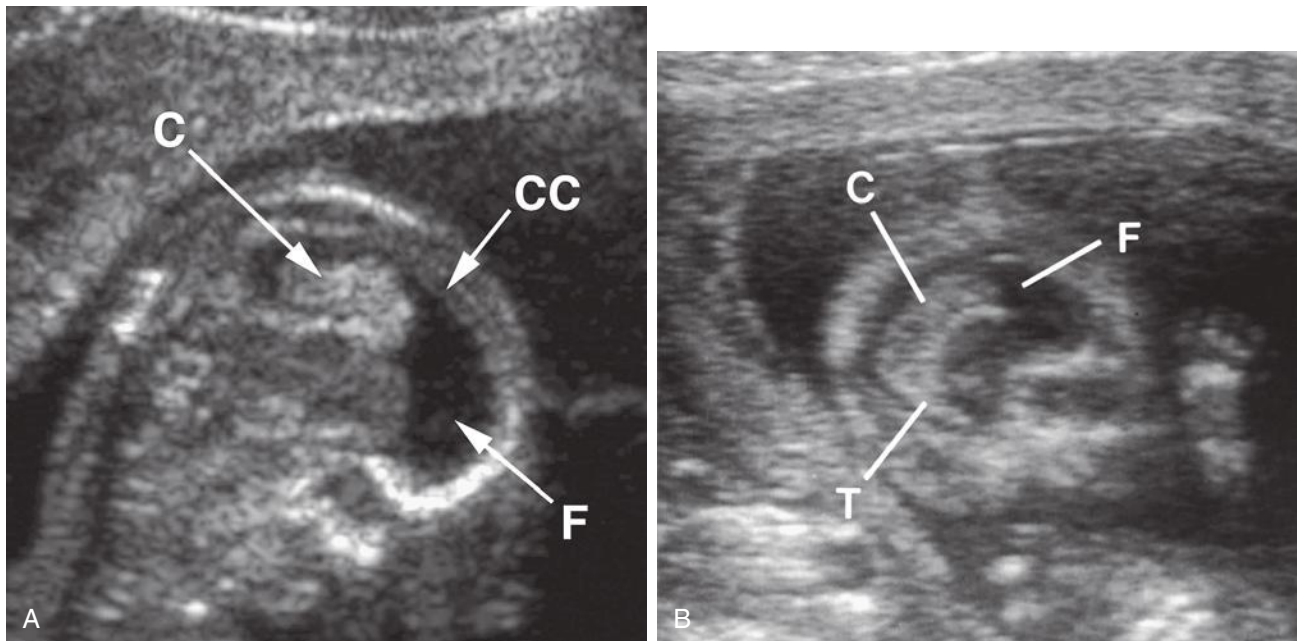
A and B, Parasagittal sonograms in late first trimester demonstrate that, even this early in development, choroid plexus (C) fills the posterior and inferior portions of the ventricle. Specular reflectors demarcate the frontal horn (F), which is devoid of choroid plexus and thus seen as a “fluid-containing” portion of the ventricular system. The early temporal horn is seen (T). Note absence of an occipital horn. Choroid plexus fills the body, atrium, and early temporal horn. Note as well how remarkably thin the cerebral cortical (CC) tissue is.
